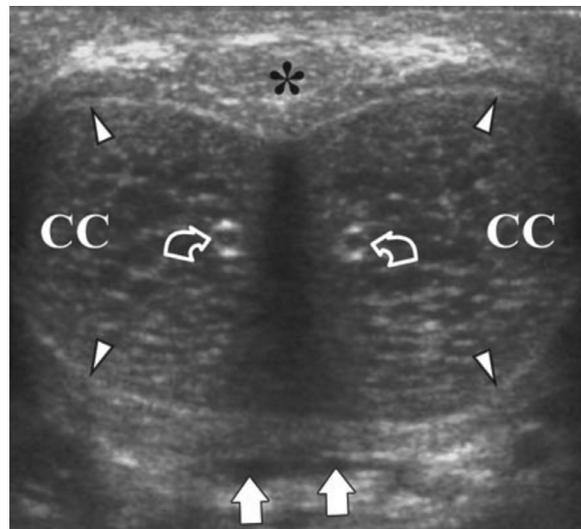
Normal penile anatomy displayed by transverse ultrasonography image shows the corpora cavernosa and the corpora spongiosum (*). The cavernosal arteries are identified by the curved arrows, the dorsal vessels are identified by the solid arrows, and the tunica albuginea is identified by the arrowheads. (Image used with permission from Radiographic Society of North America: Bertoloto M, et al. *RadioGraphics* 2009;29:477–493.
